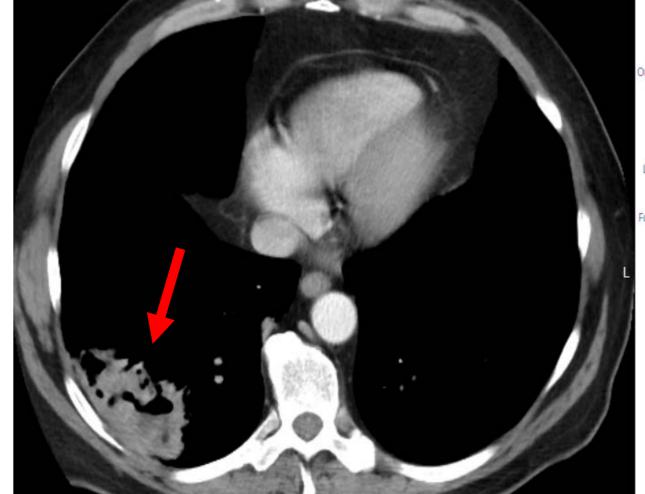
CT scan of Case 2 showing cavitary pneumonia
